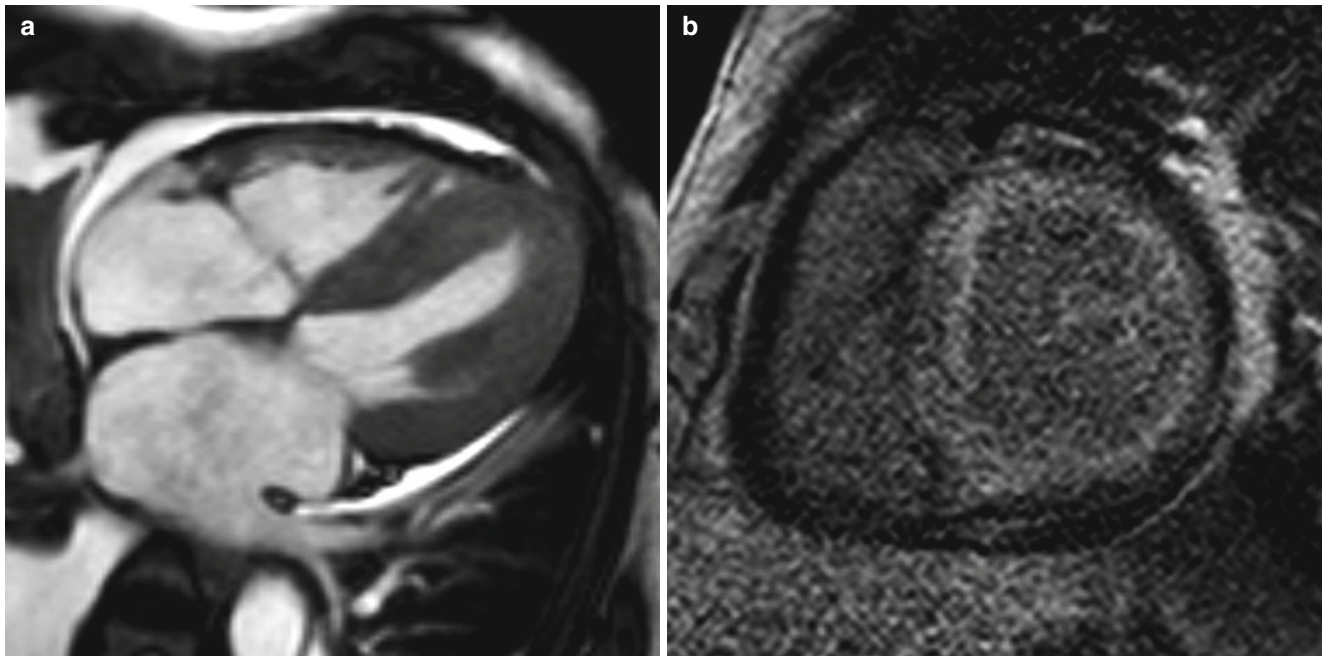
MRI of a patient with multiple myeloma and cardiac amyloidosis. (a) Four-chamber cine MRI shows mild concentric LV hypertrophy with enlarged left atrium and pleural and pericardial effusion
